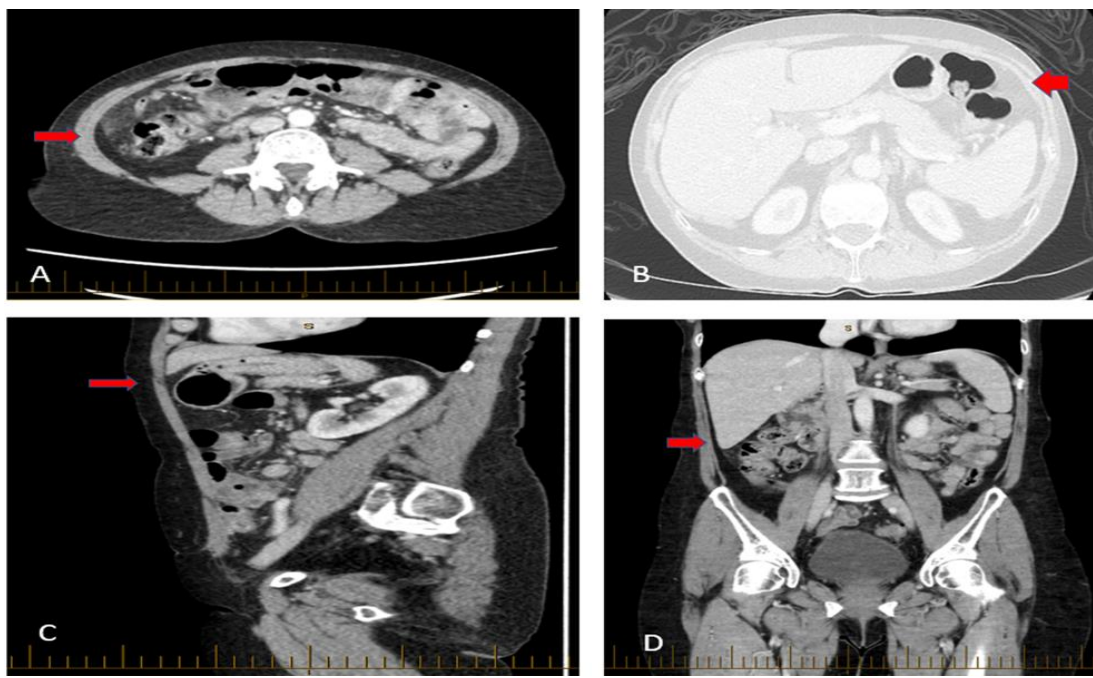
Computed tomography showing cecum is displaced into the right upper abdomen. Without distension of the proximal ascending colon
